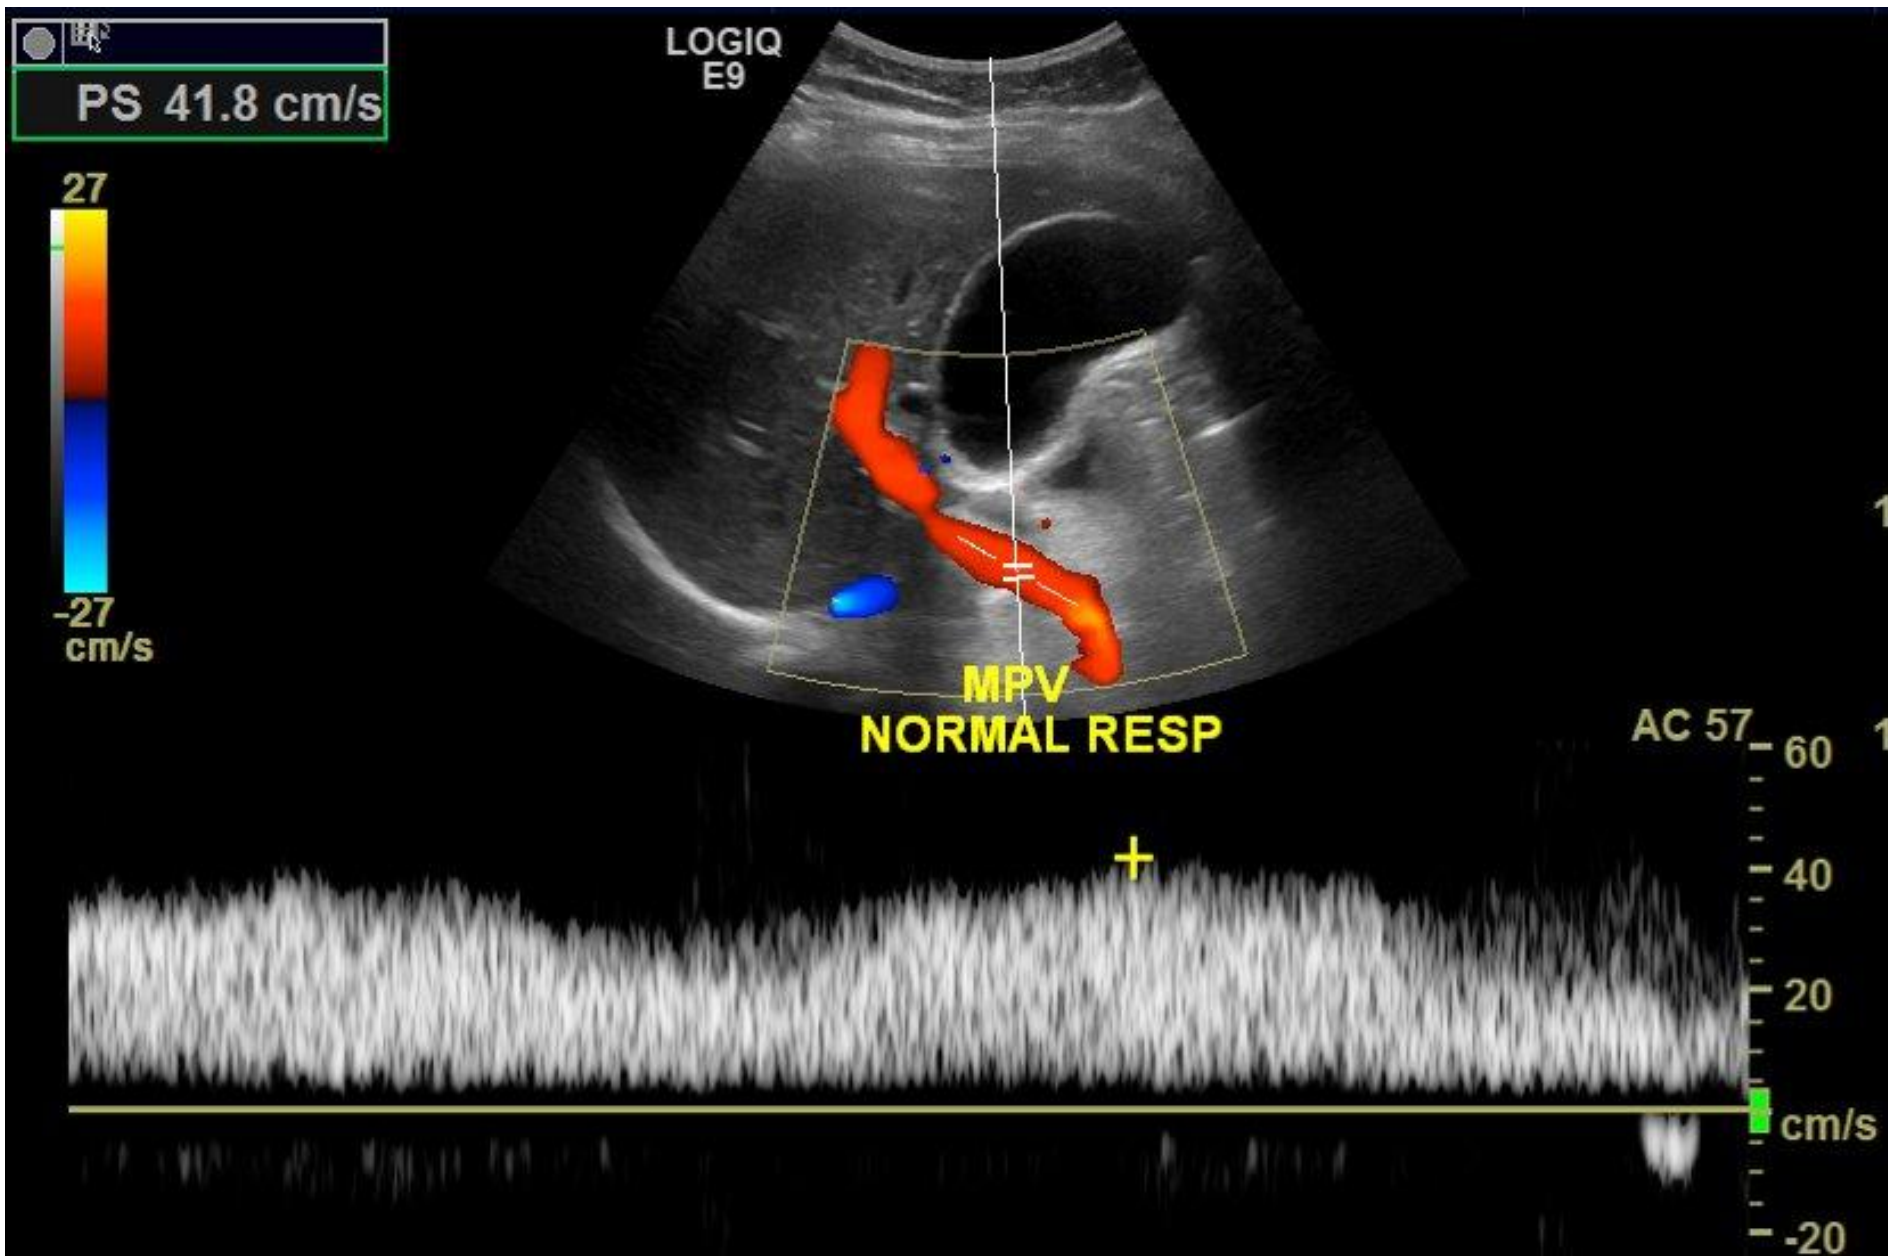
Ultrasound showing patent portal vein in a morbidly obese patient prior to laparoscopic sleeve gastrectomy
